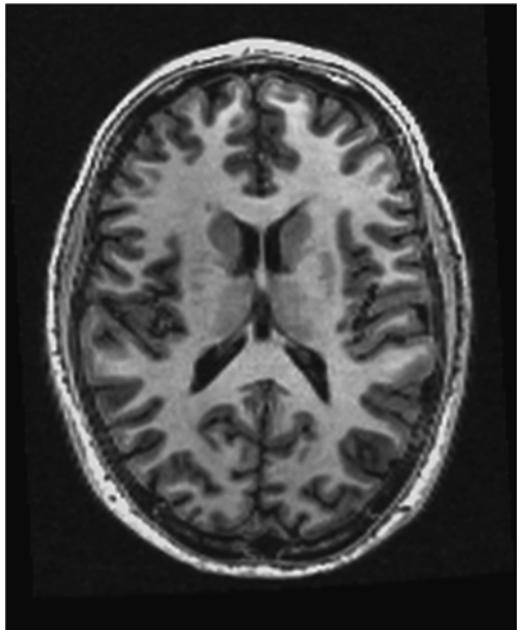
Example of an anatomical and structural MRI
